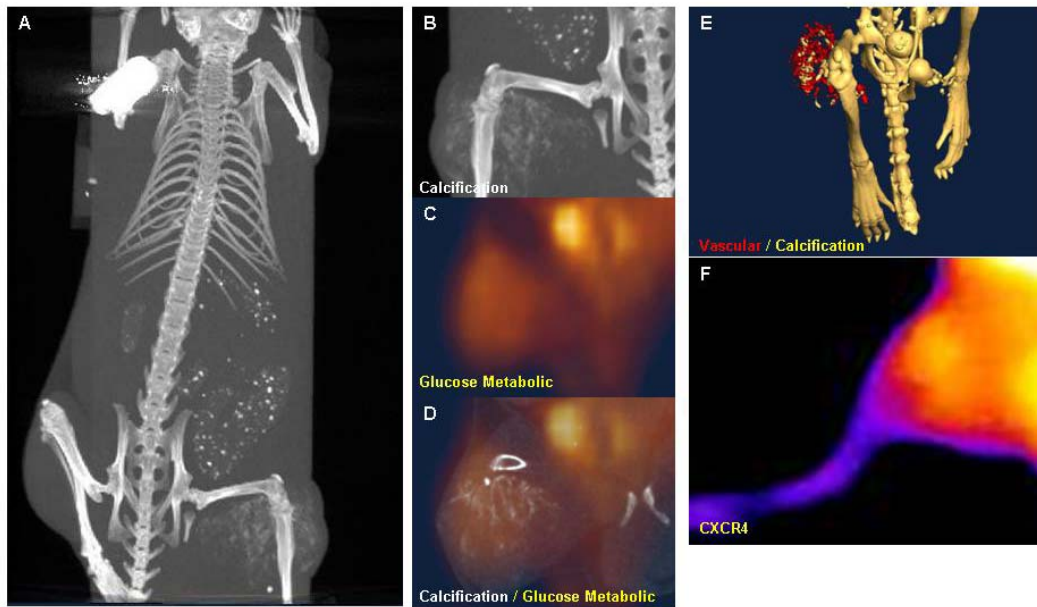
High magnification of in vivo images of osteosarcoma disease status. A. Whole-body CT image showing the tumor location with calcification. B. CT image demonstrating calcification in the tumor region. C. FDG-PET image showing a high level of glucose metabolism in the same region. D. Merged CT and PET images of B and C. E. Merged CT skeletal image and vasculature contrast images showing hypervascularity and calcification in the tumor region. F. Optical image showing strong CXCR4 signal in the tumor region.
